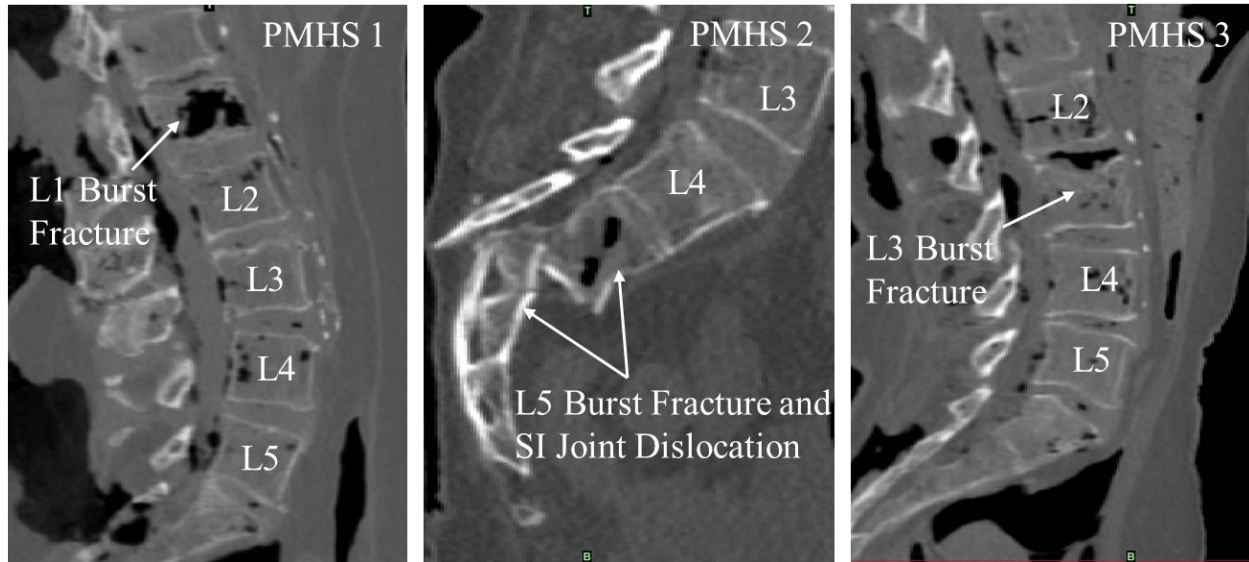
Burst fractures in PMHS 1, 2, and 3 were confirmed initially with CT scans.
